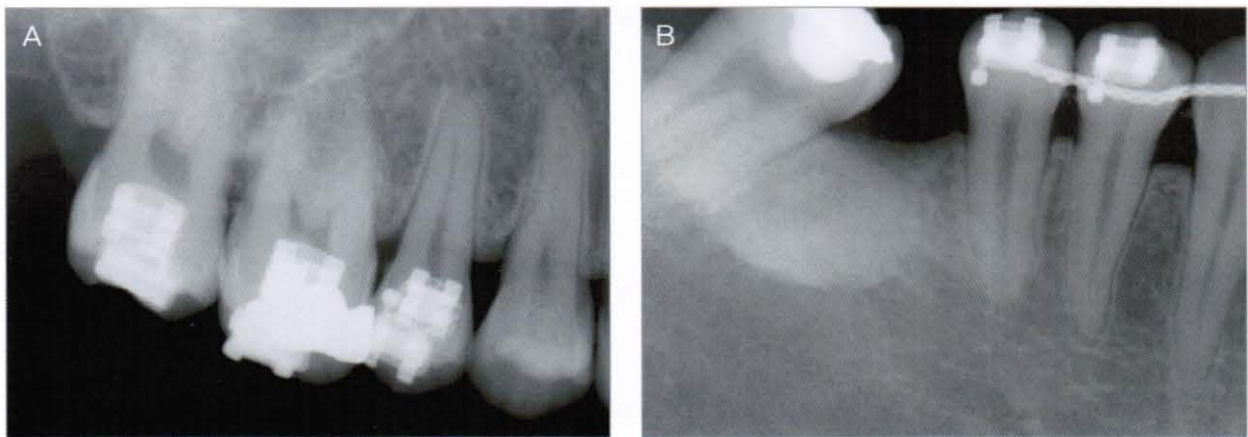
Periapical radiograph taken to visualize interradicular distances for mini-implant insertion (2006, 5,23)
